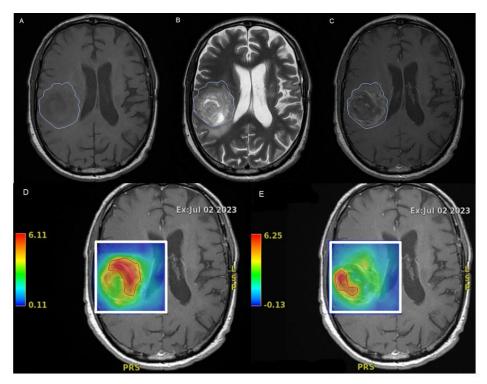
Structural magnetic resonance imaging of the brain in patients and structural contouring of ROIs on A) T1-weighted image, B) T2-weighted image, C) T1 post-Gd image (blue lines). Metabolic ROIs D) Cho/Cr, C) Cho/NAA with different thresholds (red lines).
